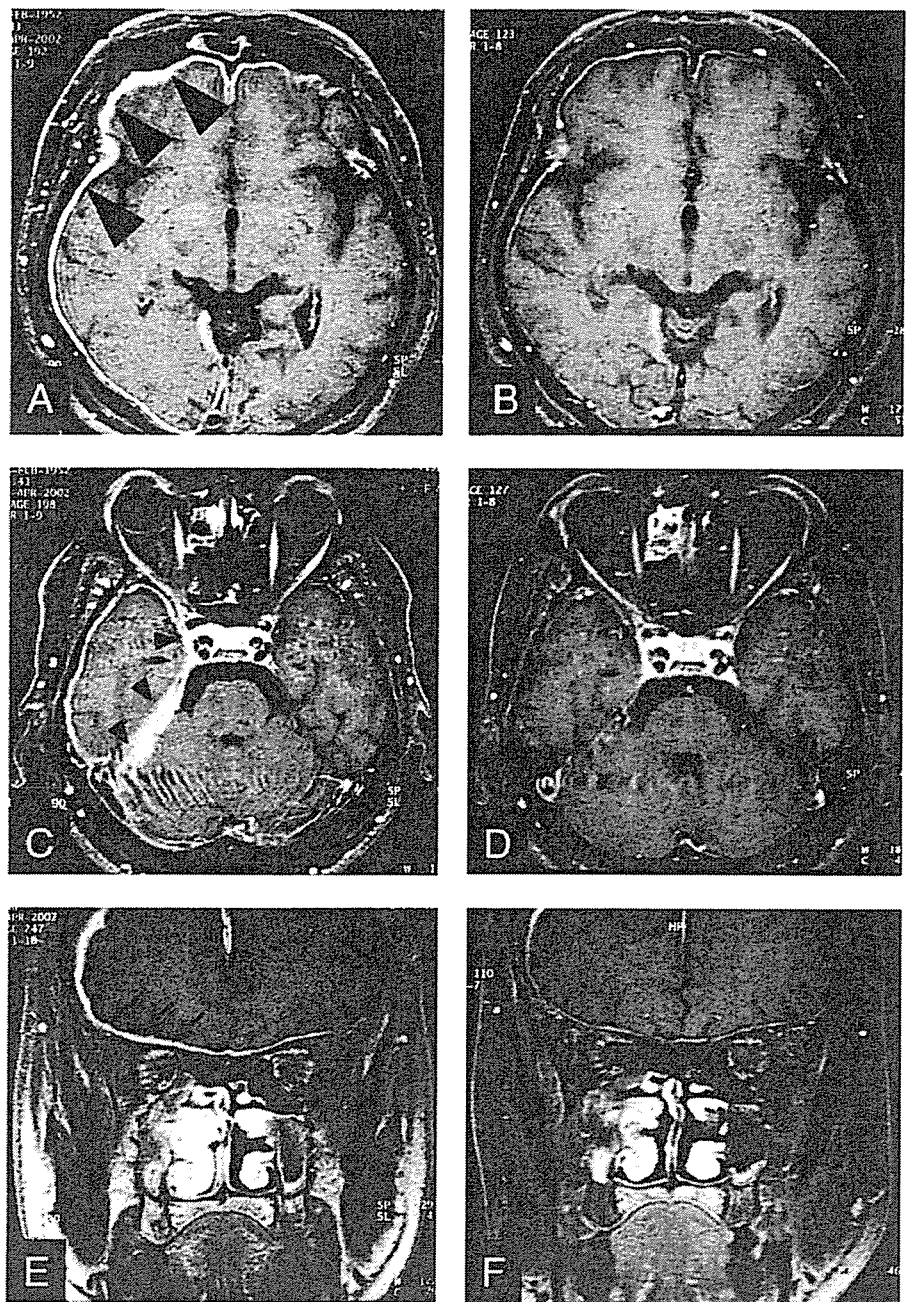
Gadolinium-enhanced T1-weighted brain magnetic resonance image on admission (A, C, and E) and 4 weeks after treatment with corticosteroid (B, D, and F). Axial scan showing pachymeningeal enhancement over the right frontal convexities (A, big arrowheads), cavernous sinus, and cerebellar tentorium (C, small arrowheads). Coronal scan showing pachymeningeal enhancement along the skull base (E, arrows). All the enhanced lesions were improved with corticosteroid (B, D, and F). A–D, axial views; E and F, coronal views.
